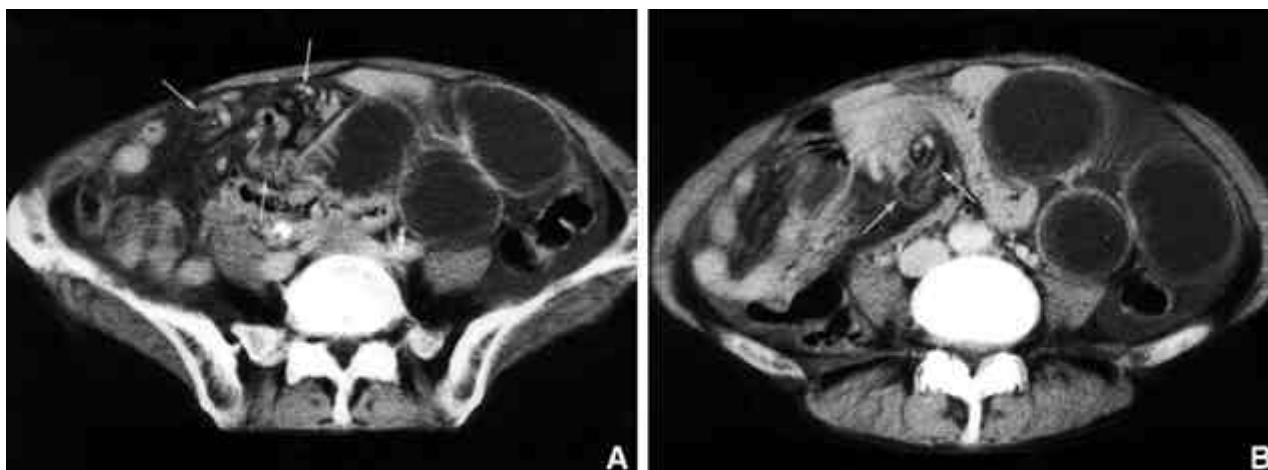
Strangulated small-bowel obstruction. A: Contrast-enhanced CT shows diffuse jejunal dilatation due to bowel obstruction. Also noted are severe mesenteric vascular engorgement (arrows) and ascites. B: Contrast-enhanced CT scan cephalad to (A) shows twisting (whirl sign) of mesenteric vessels (arrows) adjacent to the obstructed site.
